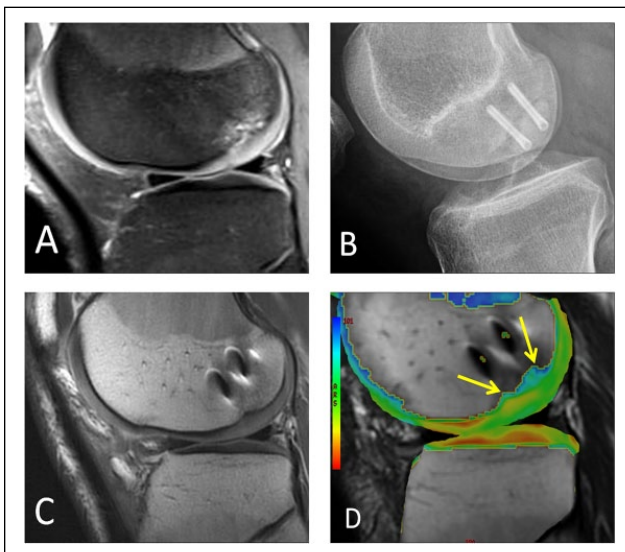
A different male patient who underwent open reduction and internal fixation of a large osteochondral lesion. (A) Large loose OCD lesion is seen on sagittal fat-suppressed proton density-weighted MRI in the lateral femoral condyle. (B) Postoperative lateral radiograph shows two metallic screws fusing the OCD lesion. (C) Postoperative sagittal proton density-weighted MRI shows integration of the fused OCD lesion with susceptibility artifact from screws. (D) Postoperative sagittal T2 mapping MRI shows prolongation of relaxation times with a lack of hyaline orientation over the central weight-bearing surface of the condyle over the lesion (arrows).
